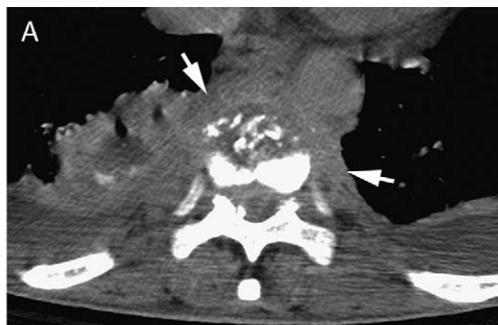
A 33-year-old female intravenous drug user with discitis and osteomyelitis. A, Cross-sectional CT image obtained on a multidetector CT scanner shows destruction of the T9 vertebral body and widening of the paravertebral soft tissues (arrows). B and C, Sagittal and coronal CT images photographed on bone window settings show destruction of the T9 vertebral body and narrowing of the adjacent intervertebral disc space. Widening of the paravertebral soft tissues is well demonstrated on the coronal (C) image (arrowhead). Blood culture grew *Staphylococcus aureus*.
